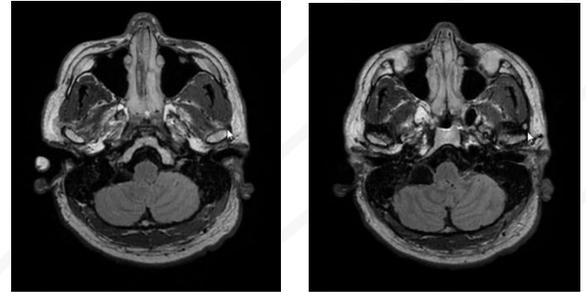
MRI showing an arachnoid cyst with mild mass effect
